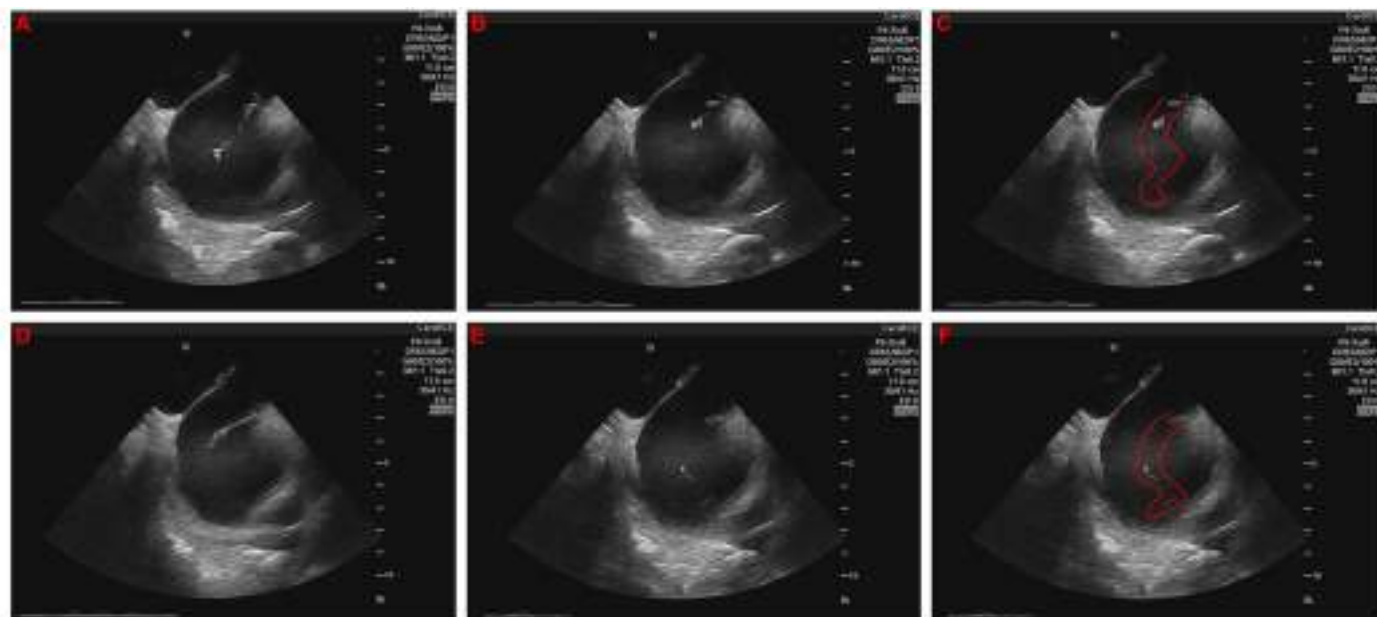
Intracardiac echocardiography images (A-F) of a serpiginous thrombus swinging from the tip of the introducer in the left atrium, after transeptal puncture conducted for pulmonary vein cryoablation. Red markings externally to the contour of the the thrombus were delineated in some images (C, F) in order to facilitate visualization.
